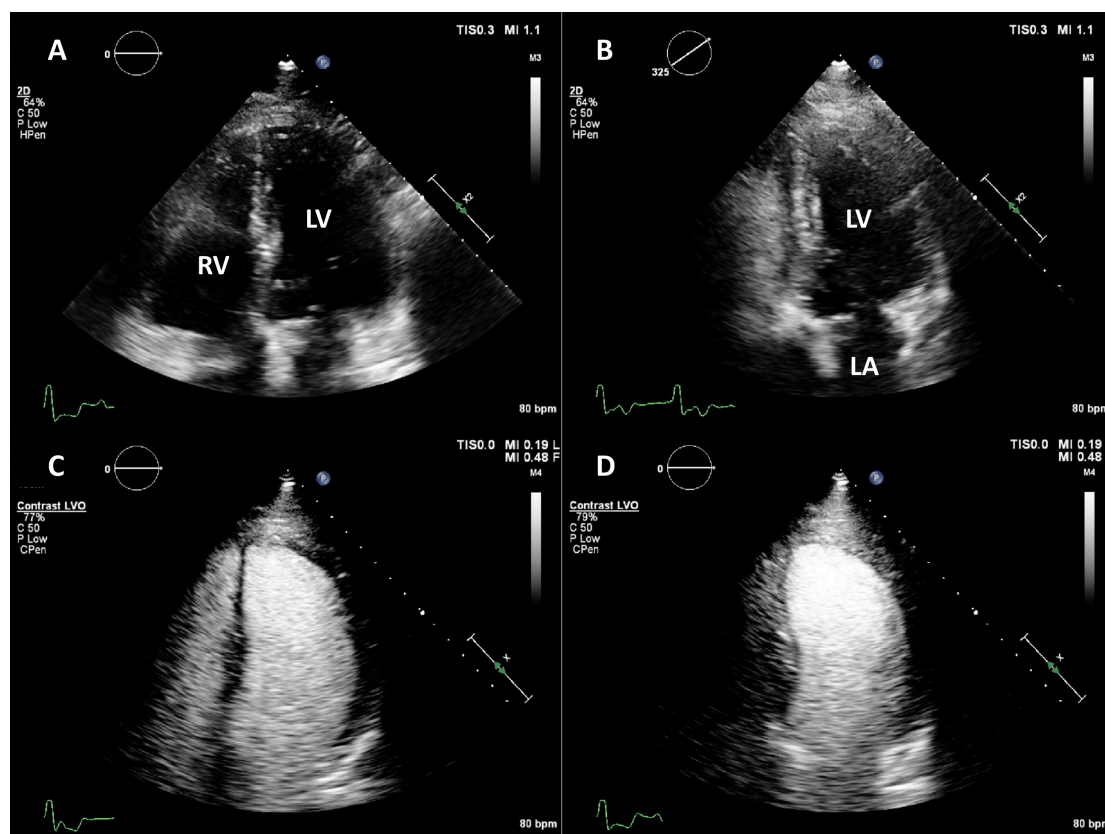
Left ventricular opacification (LVO) for endocardial border delineation. Example of baseline non-enhanced echocardiography images in apical 4-chambers (A) and apical 2-chambers (B) views, where the visualization of the endocardium is suboptimal over several segments. After intravenous injection of a bolus of UEA, there is full opacification of the LV cavity, with clear delineation of the endocardium in all segments (C, D). Source: personal collection.
